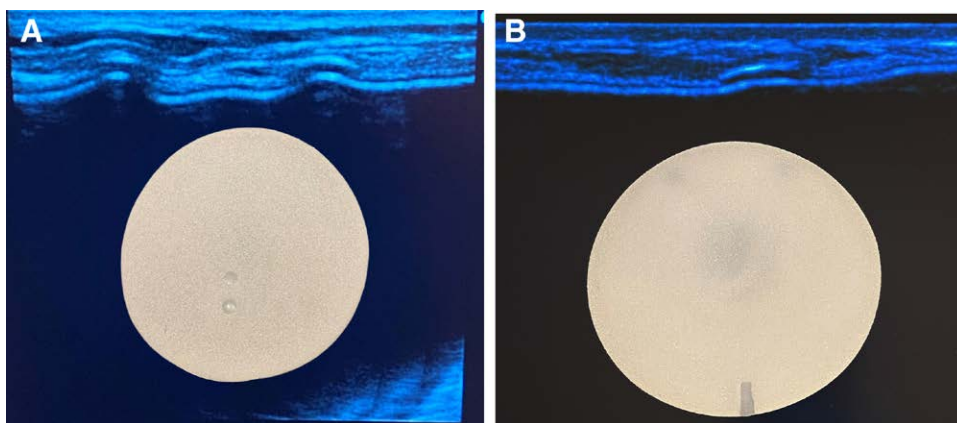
A, Silicone projection on Allergan's 410 gel implant as seen on ultrasound. B, Silicone projection on Mentor CPG gel implant as seen on ultrasound.
